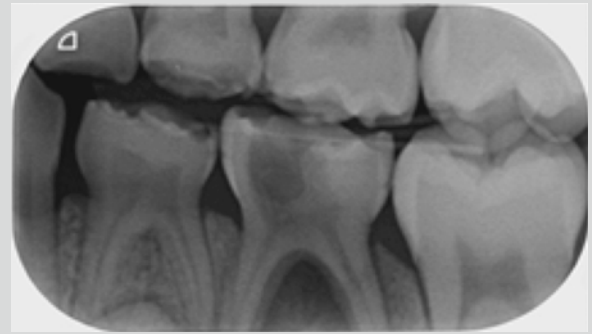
Radiographically, the lower left second primary molar shows a radiolucency in the furcation extending down part of the root indicating it was non-vital
